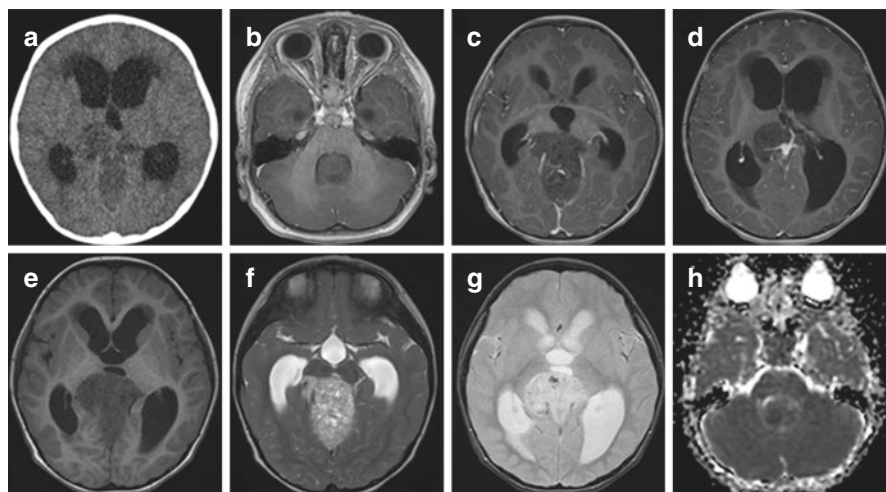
Neuroimaging of AT/RT. (Patient example from our own institution, Neurosurgical Service, KK Women's and Children's Hospital). Brain imaging demonstrating a large heterogeneously lesion extending from 4th up to 3rd ventricle and supracerebellar region, and posteriorly into the quadrigeminal cistern. It demonstrates minimal heterogeneous enhancement with internal cystic changes and calcifications and areas of restricted diffusion. Obstructive hydrocephalus is also observed. (a) Axial CT image; (b–d) Axial T1 + C at the level of 4th ventricle, 3rd ventricle and ventricular atrium respectively; (e) Axial T1W image; (f) T2W image; (g) Axial GRE image; (h) Axial ADC image. (CT: computed tomography; T1W + C: T1 weighted with contrast; GRE: gradient echo; ADC: apparent diffusion coefficient)
